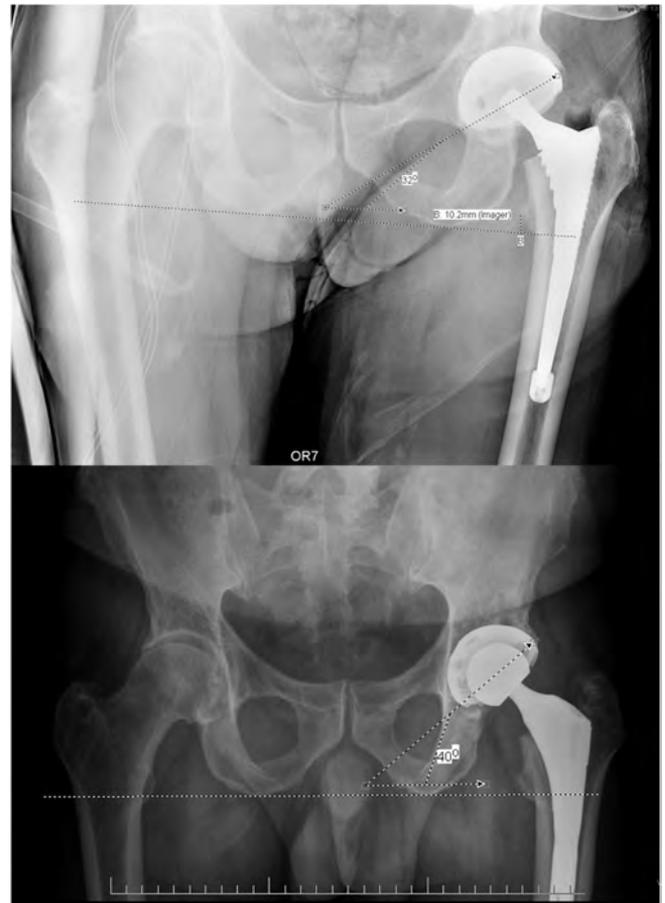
(A) Intraoperative x-ray showing trans-ischial line intersecting left lesser trochanter 10.2 mm more caudal than where the line intersects the right lesser trochanter (10.2-mm leg length inequality). Radiograph also demonstrates acetabular component excessively abducted (32°). (B) Postoperative radiograph showing trans-ischial line intersecting both lesser trochanters at similar levels, therefore equal leg lengths. Leg length corrected by resecting more femoral neck and seating femoral component more distally (acetabular alignment also improved from 32° to 40°).
